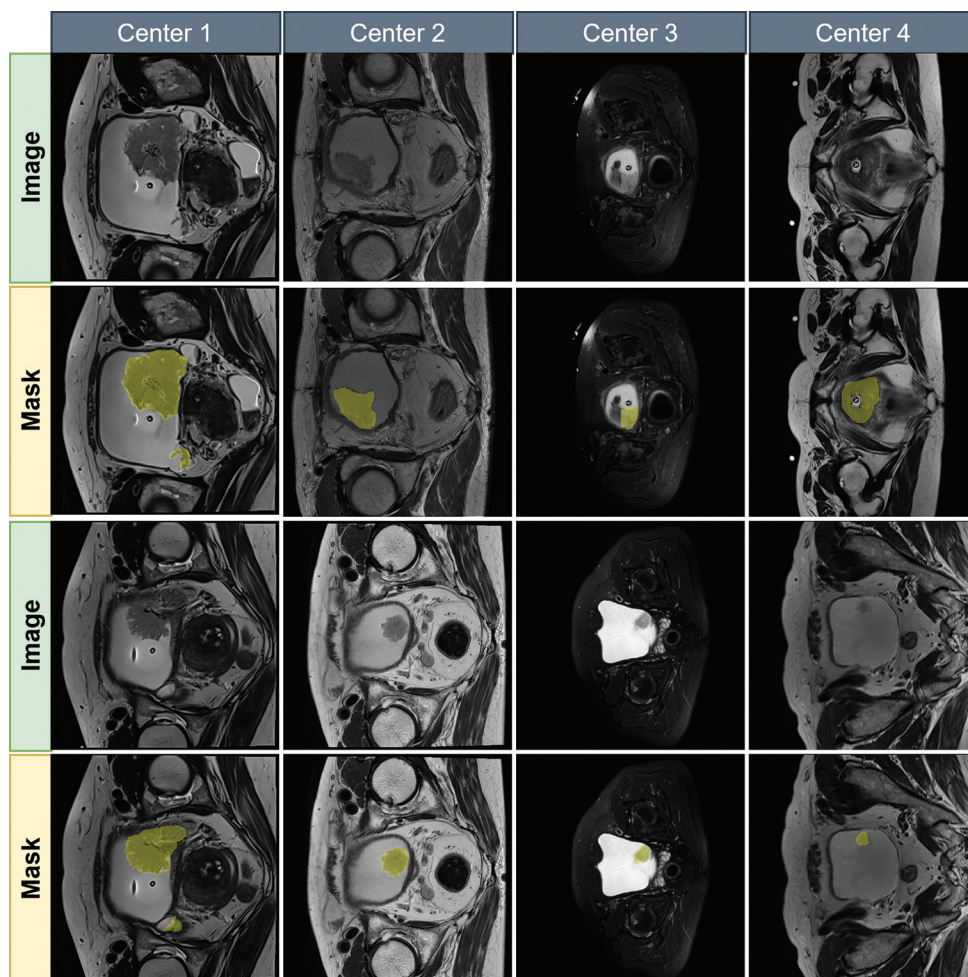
Representative magnetic resonance images and corresponding tumor masks from the multi-center bladder cancer dataset
